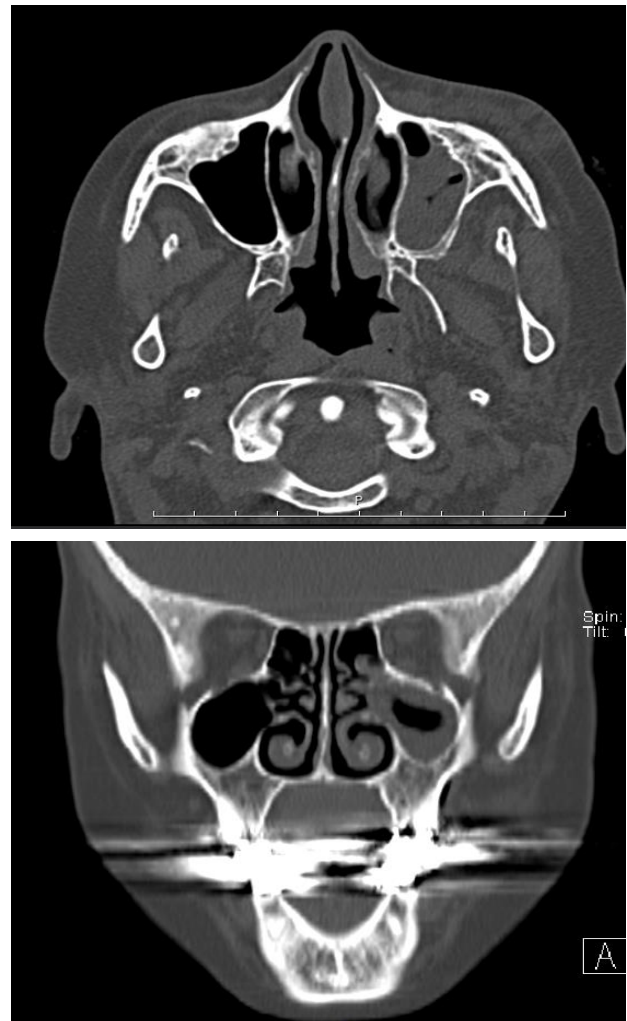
Paranasal sinus CT scan: increased mucosal thickness of left maxilla and sphenoid sinus, no bone destruction.
